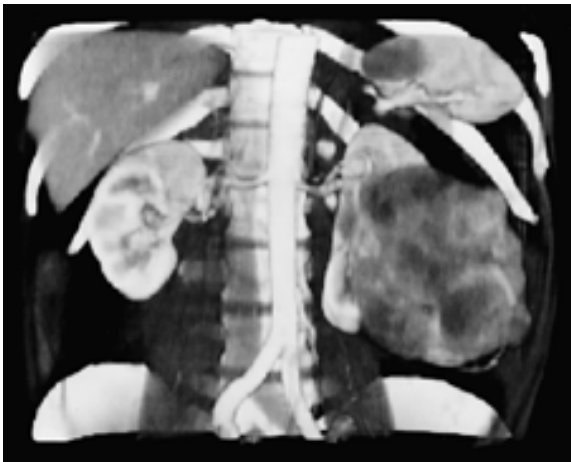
Three-dimensional computed tomography reconstruction view demonstrating excellent anatomic detail of left renal mass.
